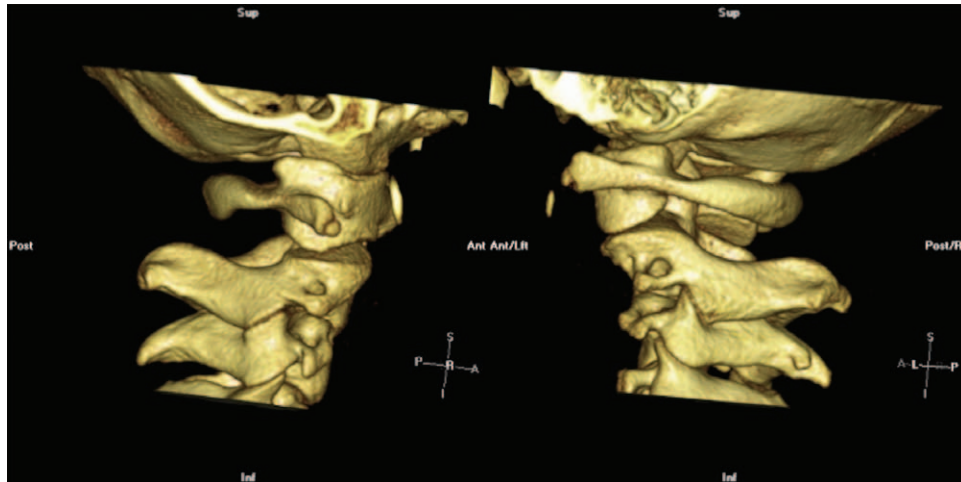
3D CT images of C1–C3 after correction with halter traction and splinting. Right and left view. Note asymmetry of C2 lateral masses.
